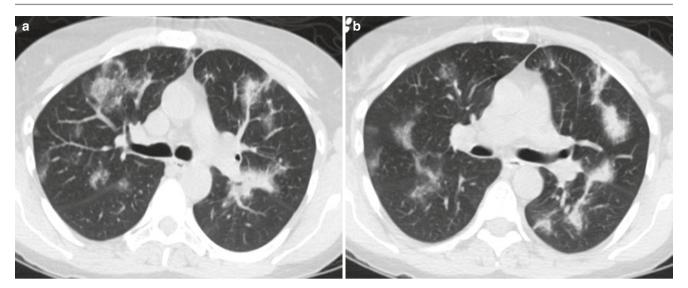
A 55-year-old woman with asthma and chronic eosinophilic pneumonia. (a, b) Axial CT images show bilateral peripheral consolidative opacities with surrounding ground-glass "halo," particularly on the left side
